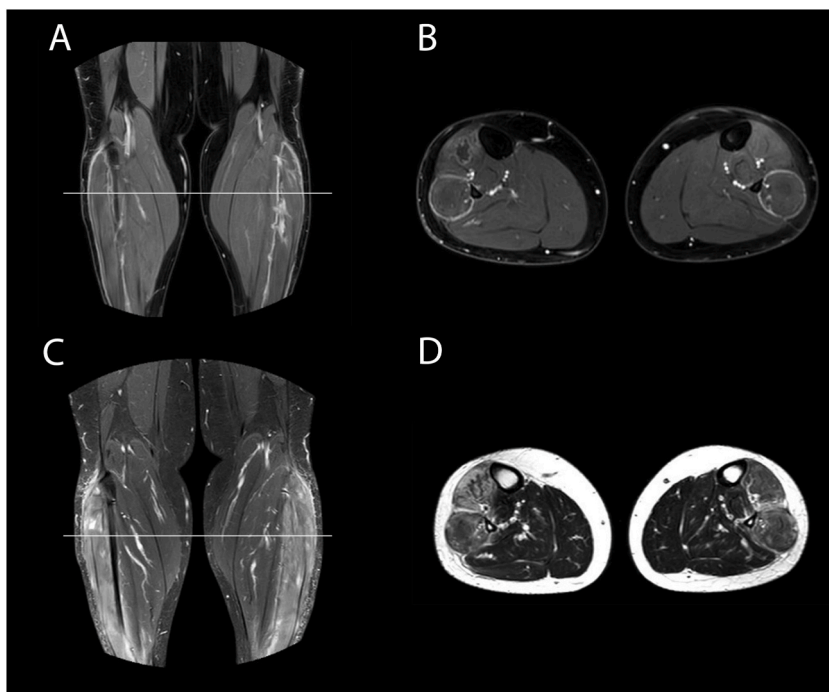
Magnetic resonance imaging of leg muscles in our patient. A and B show coronal and axial T1-weighted sequences following intravenous contrast administration; C and D show coronal and axial STIR and T2-weighted sequences. The white continuous line in coronal images (A and C) marks the section plane from which axial images were drawn.
